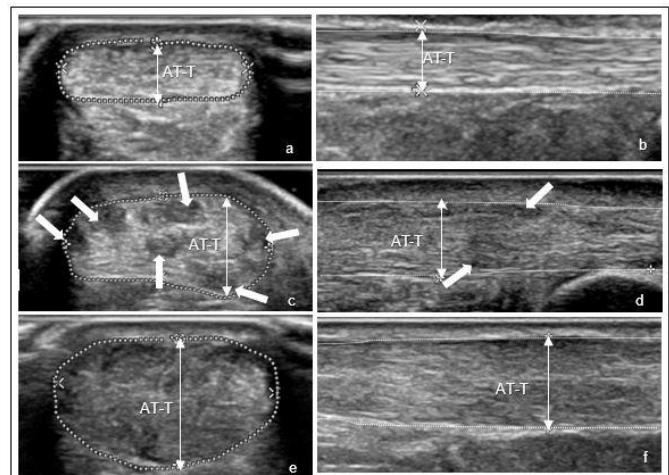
Visualisation of Achilles tendon in ultrasound
